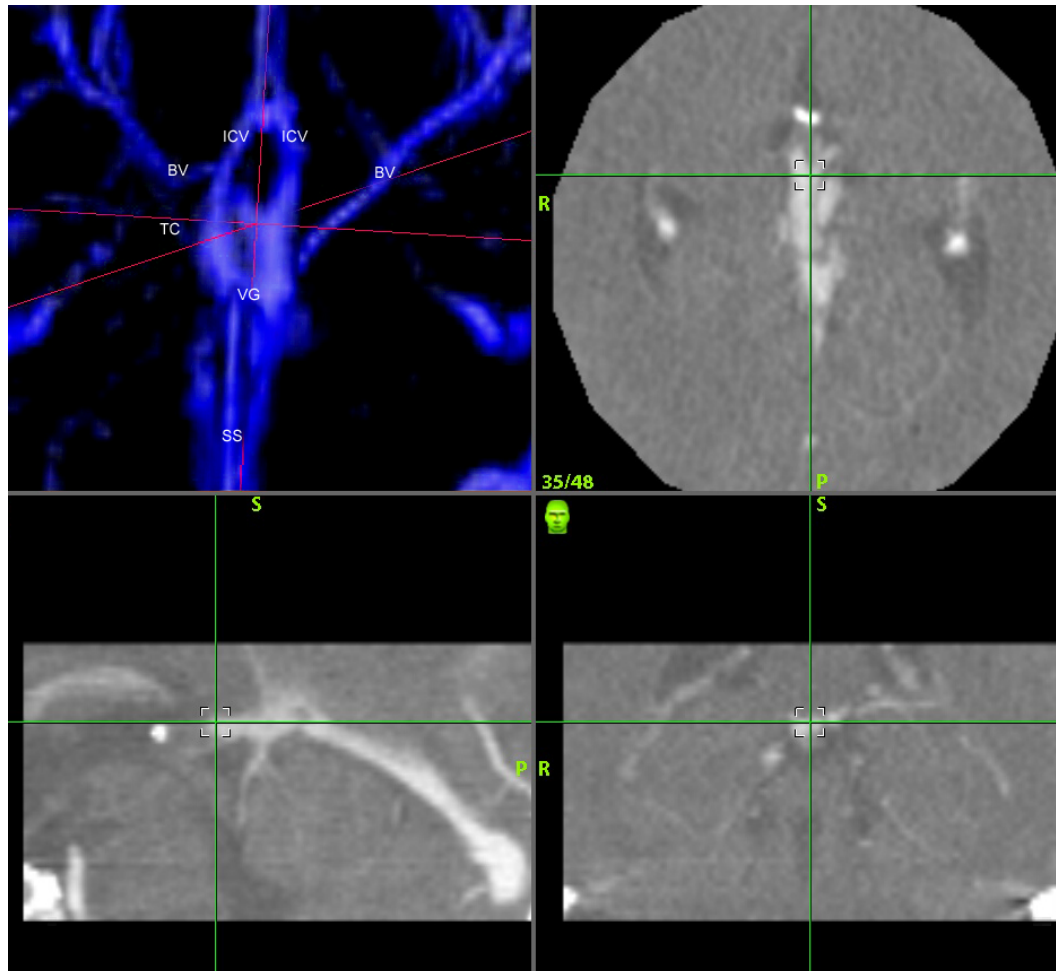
Three-dimensional reconstruction based on neuronavigation using CT images revealing a rare variant of BV drainage. The left BV on the, after its course in the ambient cistern, passes under the ICV of the same side, joining the right ICV (target point). Note that the right-upper image is a mirror of the left one. TC = thalamocaudate vein.*
